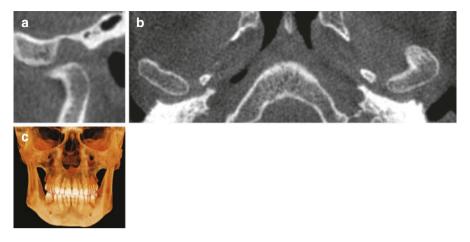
CBCT reformations show an osteochondroma presenting as an osteophyte-like projection on the anterior surface of the condyle that is directed along the muscle fibers of the lateral pterygoid (a and b). The condyle is inferiorly displaced, and this has resulted in mandibular displacement and midline shift to the right (c) (Courtesy, S. Brooks, DDS)
